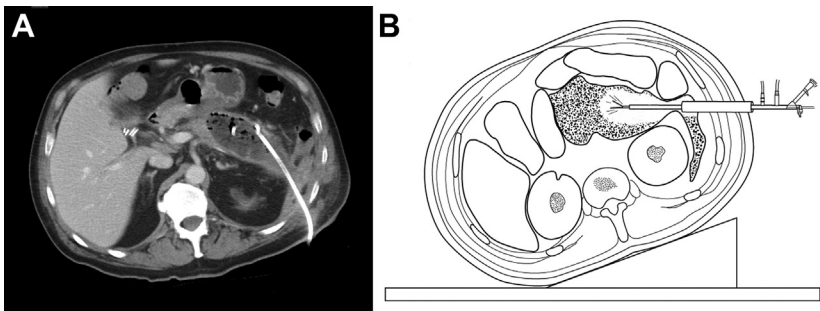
Minimally invasive retroperitoneal pancreatotomy. (A) Computed tomographic axial imaging of walled-off pancreatic collection that does not have any contact with the stomach. There is a percutaneous drain entering the collection from the retroperitoneum. (B) During a minimally invasive retroperitoneal pancreatic necrosectomy (MIRP), the drain is replaced with a sheath, through which a nephroscope with two working channels (light source and forceps) can be placed for debridement.
